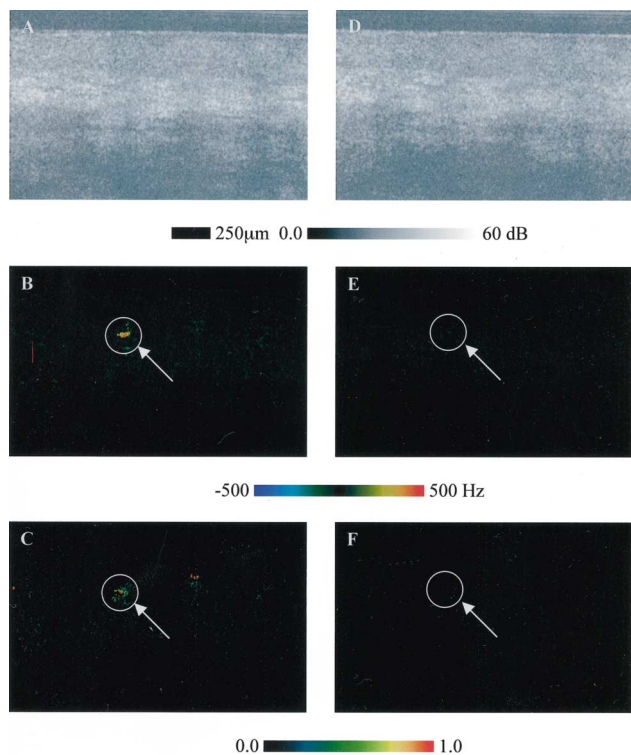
Tomographic images of identical PWS sites before (A–C) and after (D–F) laser treatment. A, D, Structural images; B, E, Doppler-shift (blood flow velocity) images; C, and F, normalized variance of flow velocity. The vessel areas are marked by circles and arrows in the velocity and variance images.
